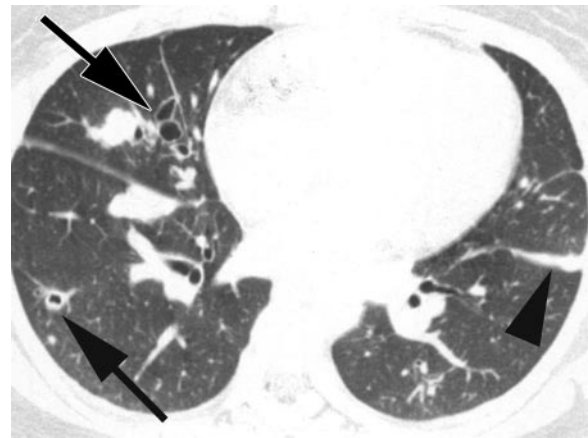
PP in a 42-year-old woman with 70% peripheral eosinophilia. A skin test for *P westermani* was positive. Transverse thin-section (1-mm collimation) CT scan (lung windowing) shows multiple nodules and thin-walled cysts (arrows) in the right middle and lower lobes. Note the linear opacity in the left lower lobe (arrowhead).
